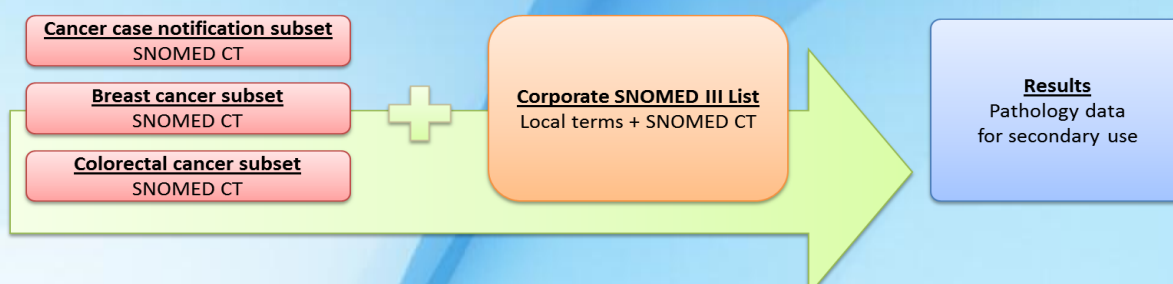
Example of using different SNOMED CT subsets for pathology data retrieval.
